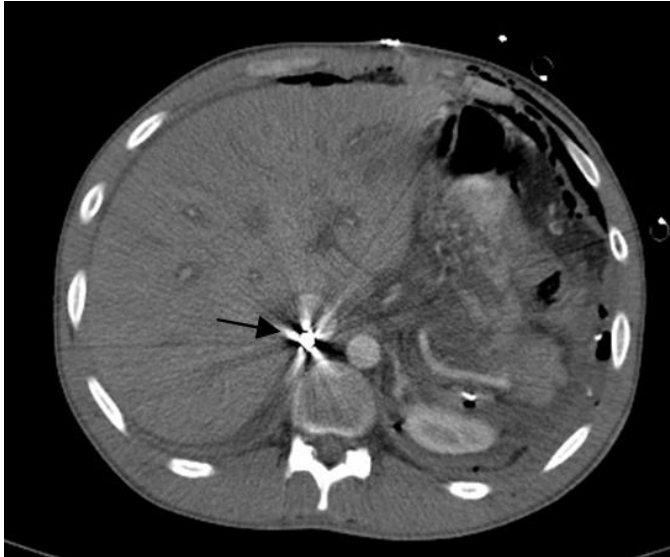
Contrast enhanced abdominal CT scan showing a bullet within the inferior vena cava (arrow).
